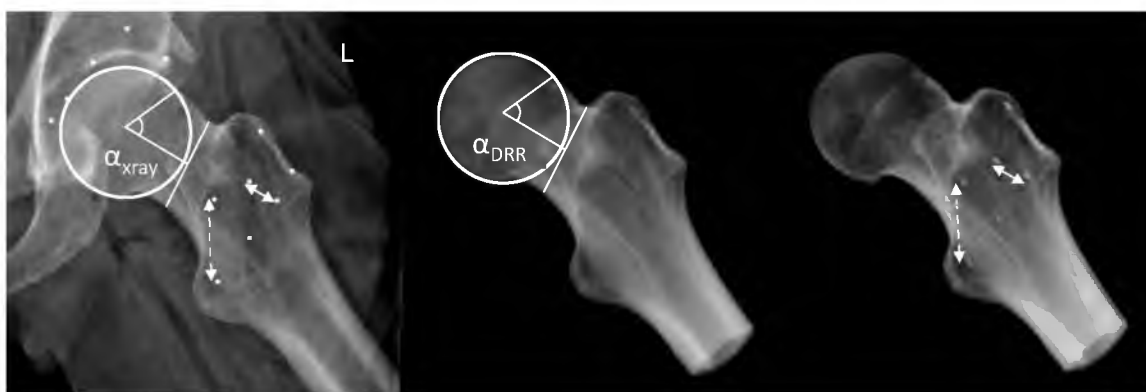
DRR validation. Beads were obscured in the CT data and a DRR image was created to match the representative traditional radiograph. Beads were then revealed and a second DRR was created using the transformation matrix used to orient the first DRR. Interbead distances and alpha angles between the DRRs and traditional radiograph were statistically compared. Dashed arrows indicate representative bead distances.
